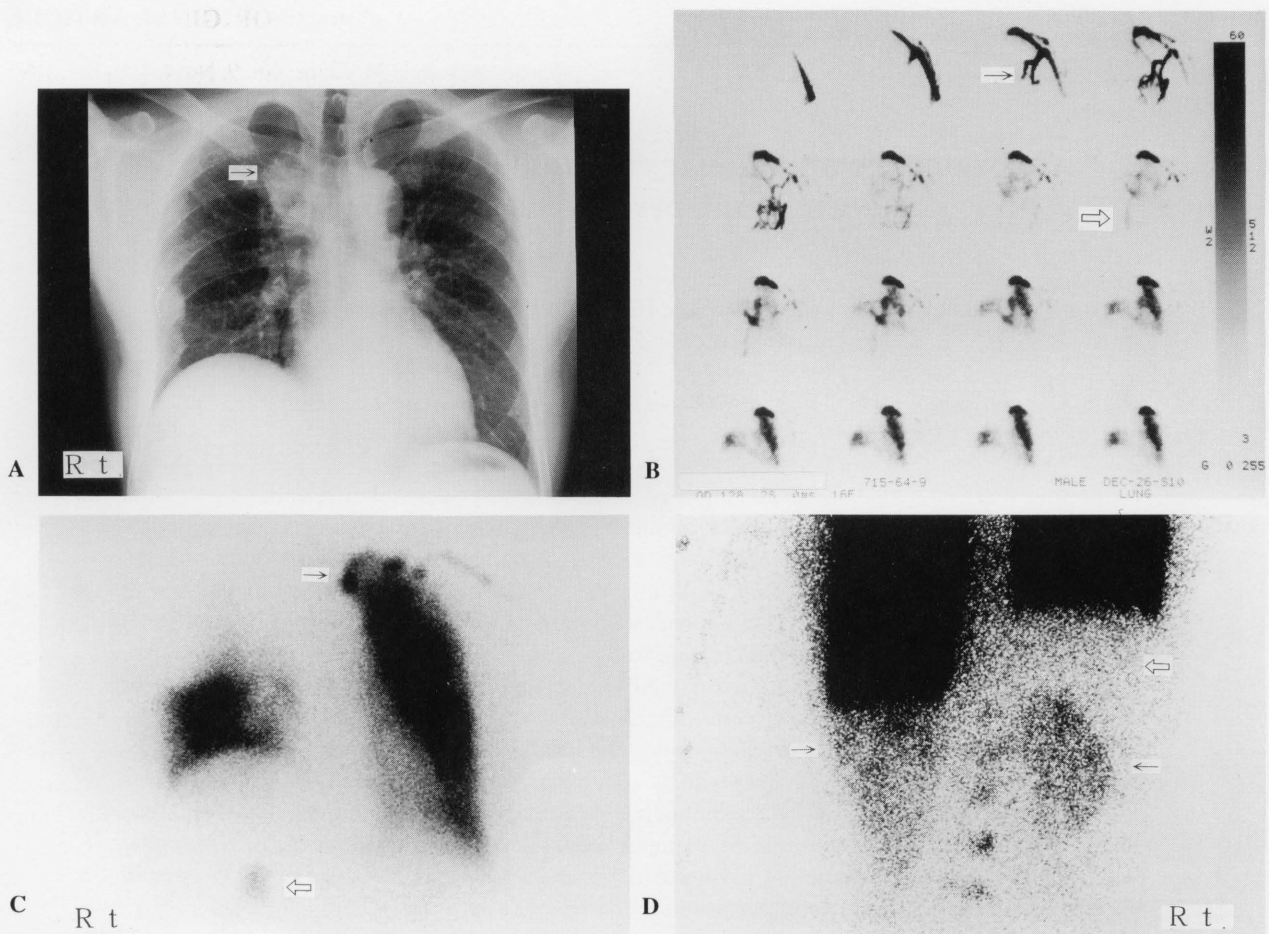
A. Posteroanterior chest X-ray showing a mass lesion adjacent to the SVC in the right upper lobe (→). B. Radionuclide venography visualized the collateral pathways, the superficial veins of the thorax (→) and IVC (⇨), immediately after depicting the left subclavian vein. C. ^{99m}Tc -MAA lung perfusion scan showing a reduced perfusion in the right upper lung field and an intense uptake in the left upper thoracic wall (→). And a "hot spot" in the hepatic hilus was noted (⇨). D. An intense uptake in both kidneys was seen (→). Compared with the activity of ^{99m}Tc -MAA in the kidneys, that of the liver was lower (⇨) (posterior view).
